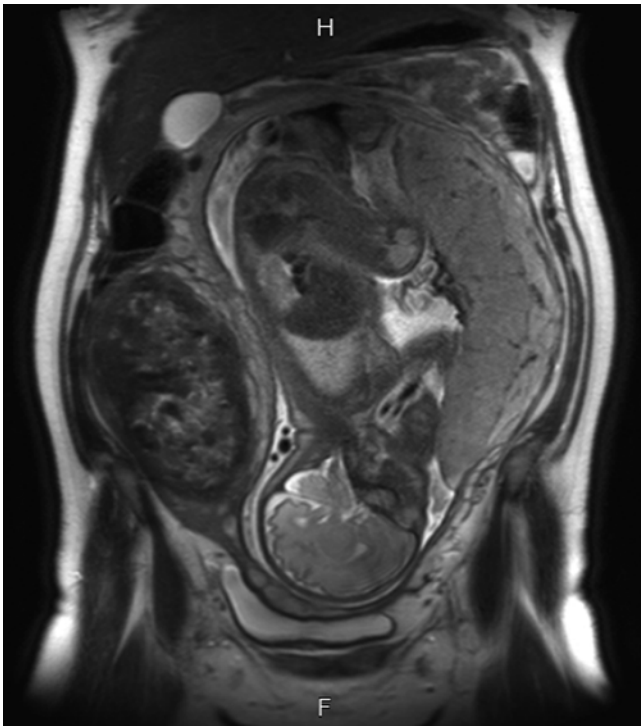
MRI scan showing a fetus in longitudinal position at 34 weeks in a uterus with a fibroid of 12 cm in diameter in degeneration (Courtesy of Prof. Dr. Josè Palacios de Jaraquemada)
